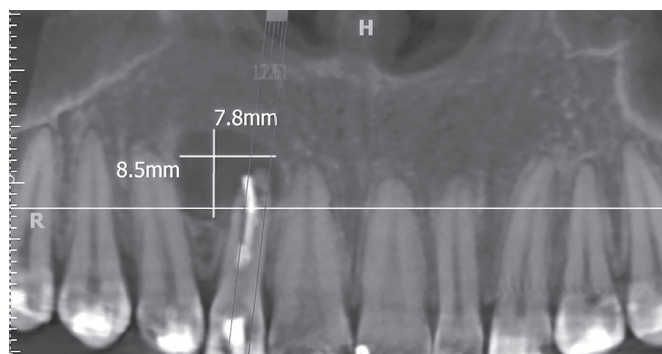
CBCT showing lesion size at baseline.
